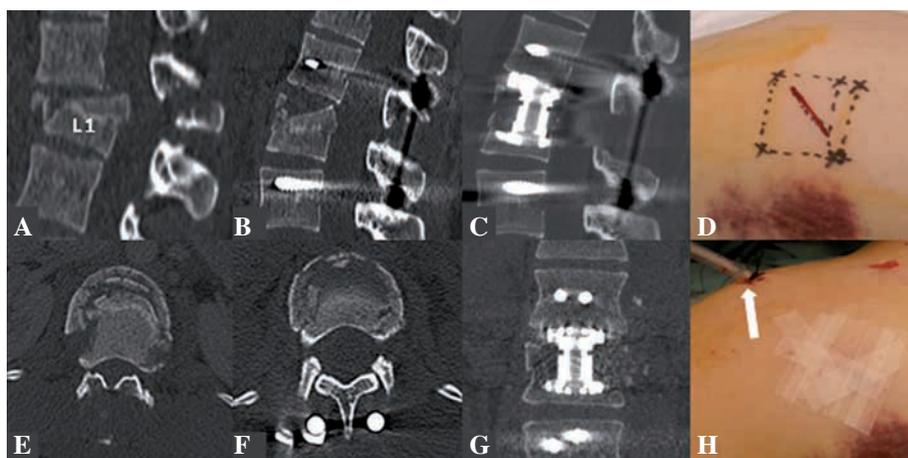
Case 6 : CT-scans : (A, E) after trauma, (B, F) after dorsal instrumentation and (C, G) after additional anterior reconstruction. Intraoperative photographs showing (D) the skin incision for the working portal and (H) insertion of a chest tube (arrow) through the anteroinferior endoscopic portal plus closure of the wound of the working portal above the fractured vertebra.
